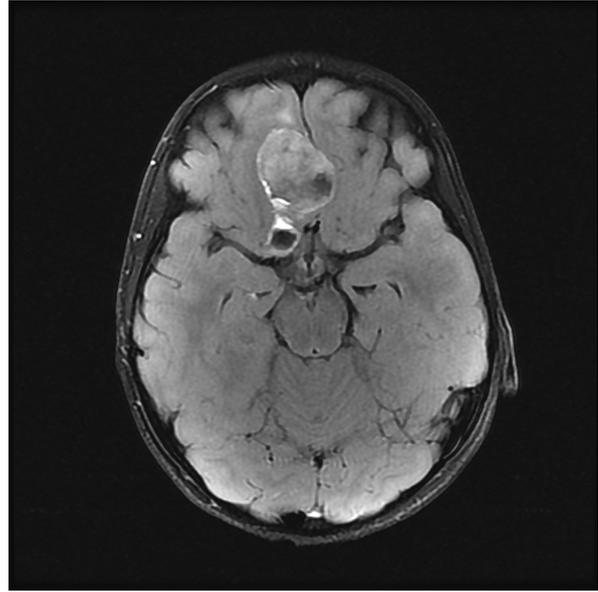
Magnetic resonance imaging brain T2 fluid-attenuated inversion recovery demonstrates a new 2.5 × 3.1cm enhancing mass along the floor of the anterior cranial fossa indicating metastasis of the patient's retinoblastoma to the brain.
